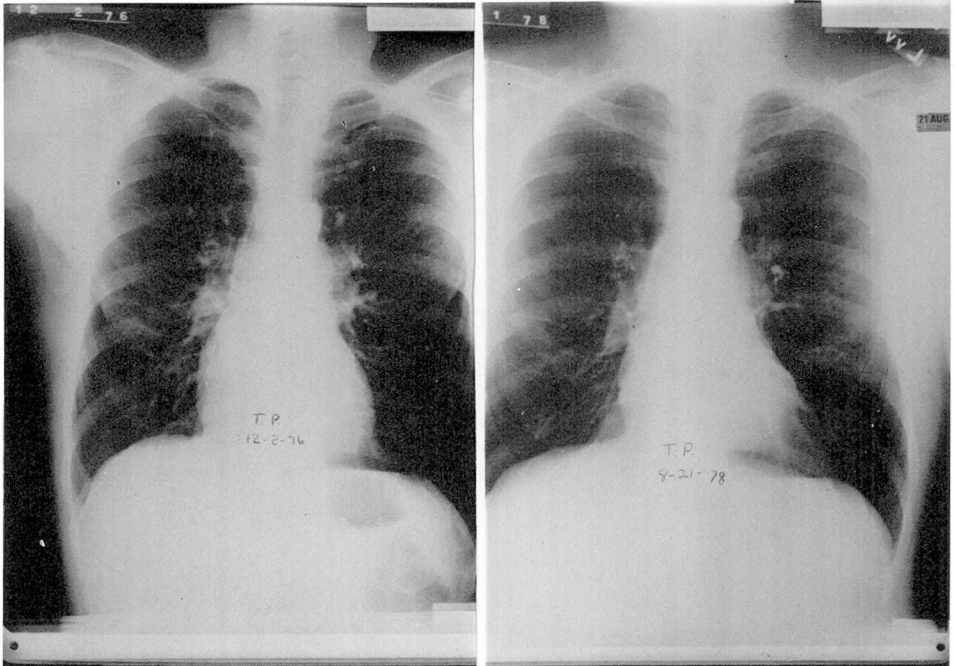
Posteroanterior chest roentgenograms of patient with obvious, severe COPD and cryptic tight mitral stenosis. Hyperinflation and prominent central pulmonary arteries are two major findings before mitral valve surgery, December 2, 1976. After surgery, August 21, 1978, hyperinflation remains, but pulmonary arteries are less prominent.
